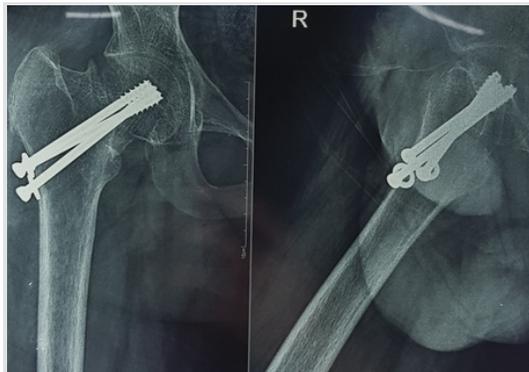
Six months follow-up radiographs.
